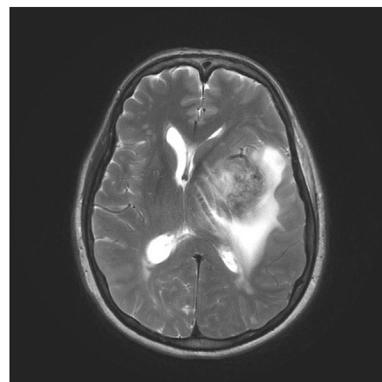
T2-weighted image showing intra-cranial tumor extension causing compression of the left lateral ventricle and midline shift to the right. Surrounding white matter edema.
